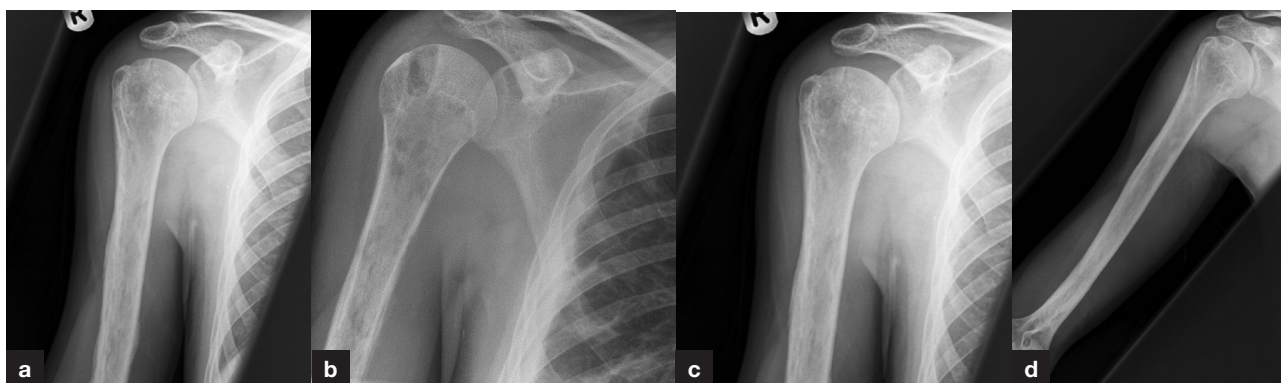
a. Radiograph of an 18-year-old male, with insulin-dependent diabetes mellitus, who was admitted to the intensive therapy unit with sepsis and pan-diaphyseal osteomyelitis. He had life-threatening infection which was treated in intensive therapy unit. Orthopaedic treatment was performed to prevent recurrence and remove the infected material from the humeral shaft by reaming the humeral canal. b. Surgical reaming of the humerus has been performed and infected material removed. c. Radiograph 6 months post-surgery shows improvement with reduced lysis in bone and healing periosteal reaction. d. Radiograph 12 months post-surgery showing near-normal looking humerus.
